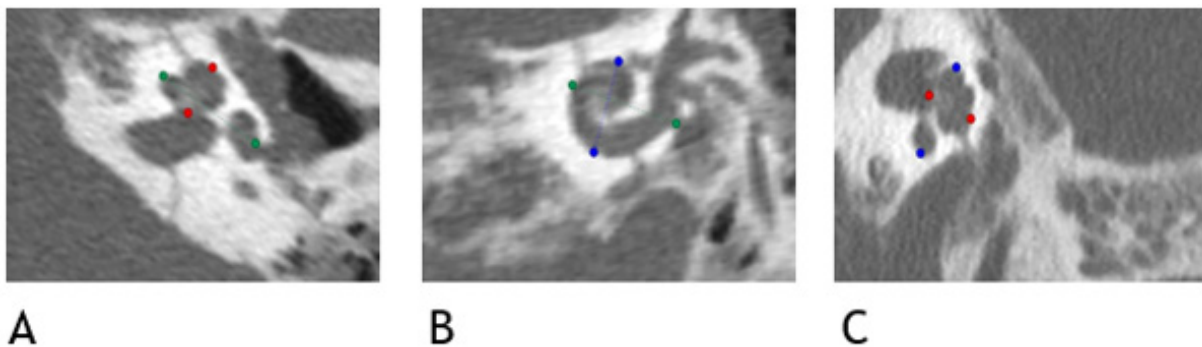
OTOPLAN-based measurements of the preoperative CT scans: (A) A value (green dot on red line), (B) cochlear width (B value; blue dot on red line), and (C) cochlear height (H value; red dot on green line). Axial, coronal, and sagittal CT views are shown.
